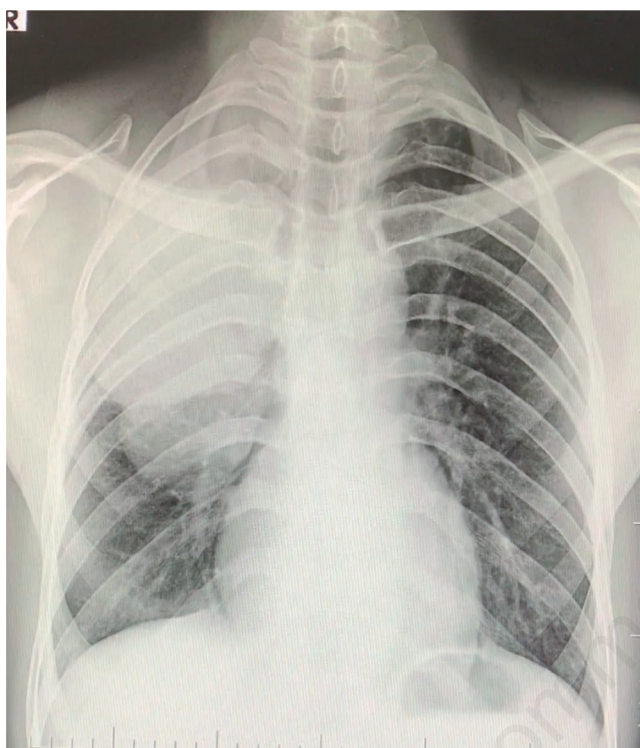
Chest radiograph showing a homogenous well-defined opacity in right upper and middle zone.
